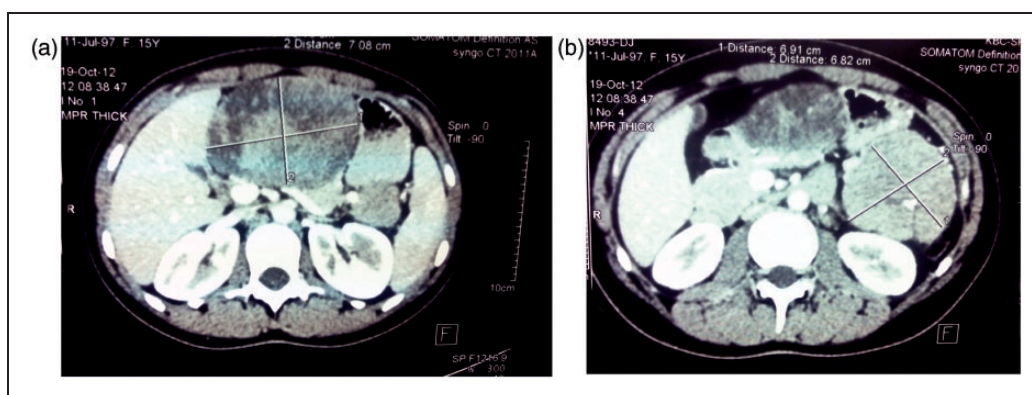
Computed tomography showed two circumscribed encapsulated heterogeneous masses with solid and cystic areas and calcifications. (a) Tumour arising in the head of pancreas and (b) tumour arising in the tail of pancreas.
